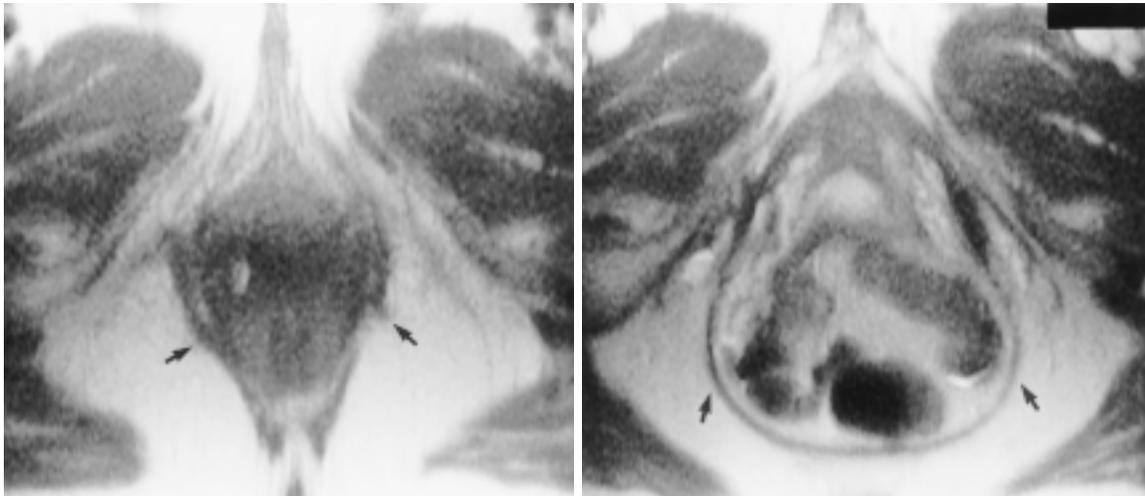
Increase in pelvic hiatus area in the same patient as in Figure 13a and 13b. Axial T2-weighted MR images of the pelvis obtained with the patient at rest (a) and straining (b) show how the area enclosed by the levator ani muscles increases as the small bowel prolapses and the pelvic floor descends during straining (arrows).
